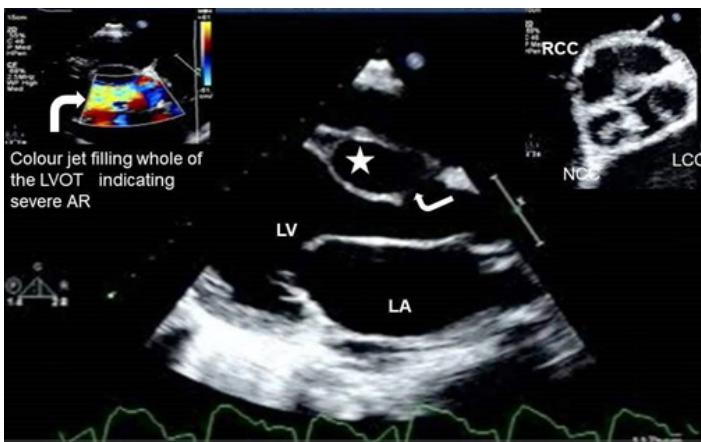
Parasternal Long axis view is showing dilated Left atrium, dilated left ventricle along with an aneurysm burrowing into the interventricular septum (*) with the rent from the aortic sinus shown by the arrow. The upper left image is showing the color Doppler across the left ventricular outflow tract indicating severe aortic regurgitation. The upper right image is showing the three cusps of the aorta in diastole, leading to incomplete coaptation causing aortic regurgitation. Abbreviations: LA – left atrium, LV – left ventricle, RCC- right coronary cusp, LCC – left coronary cusp, NCC- noncoronary cusp, LVOT – left ventricular outflow tract, AR- aortic regurgitation.
